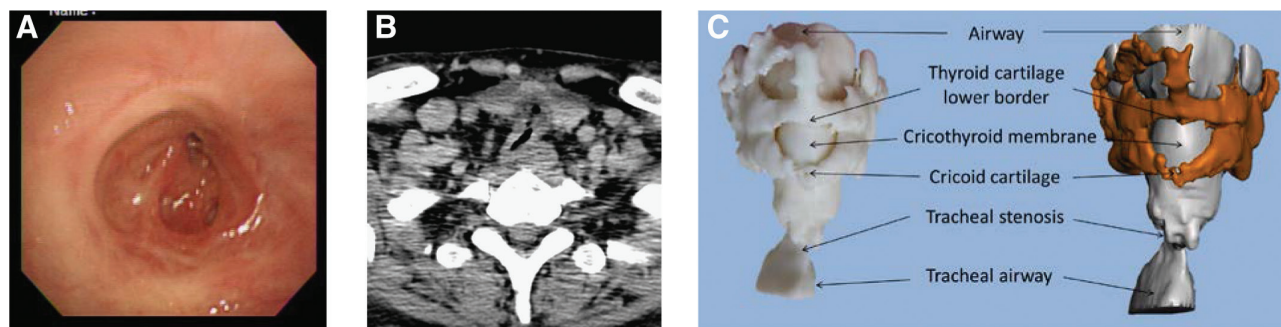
Trachea stenosis (A) laryngoscopy, (B) chest computed tomography image. C, Reconstructed 3D model of the upper airway thyroid cartilage and cricoid cartilage. Note that the thyroid cartilage was not fully ossified at the upper border and bilateral lamina, which are visible as a defect on the image.
